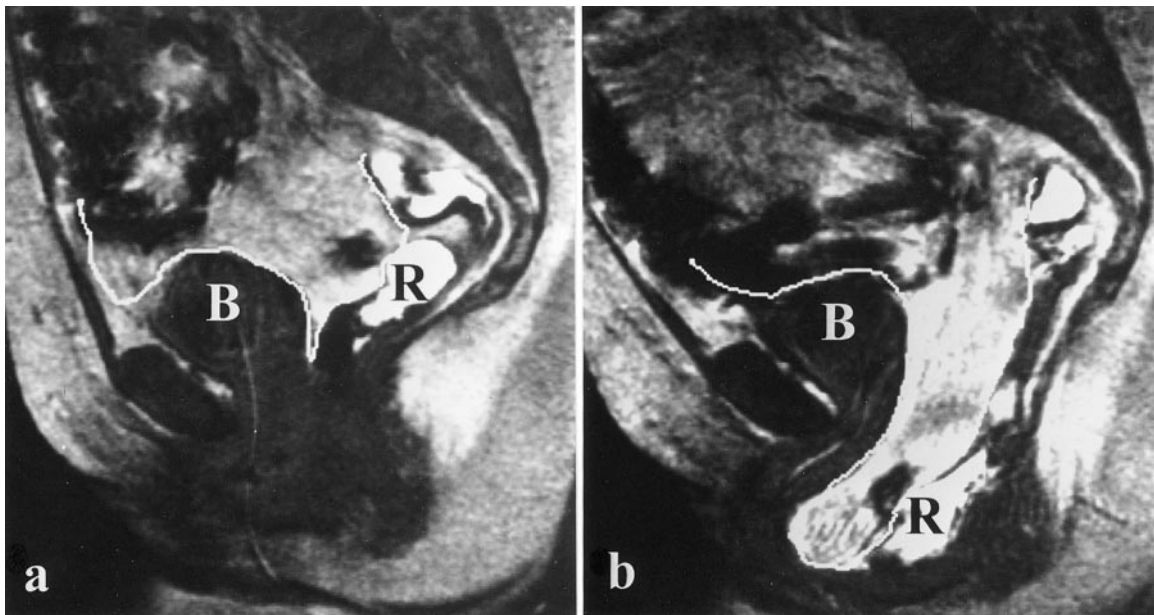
Sagittal MRI of the pelvis at rest (a) and during Valsalva maneuver (b) in a 56-year-old patient with vaginal prolapse following vaginal hysterectomy with vaginal repair in 1983 and repeated vaginal repair in 1988. Enterocele (indicated by the line) and rectocele (R) occurred during the Valsalva maneuver. B, bladder.
